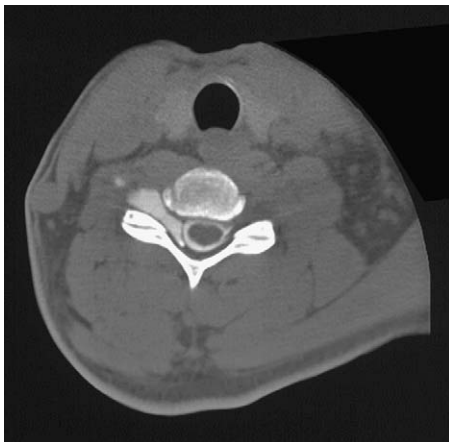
CT myelogram of nerve root avulsion.
